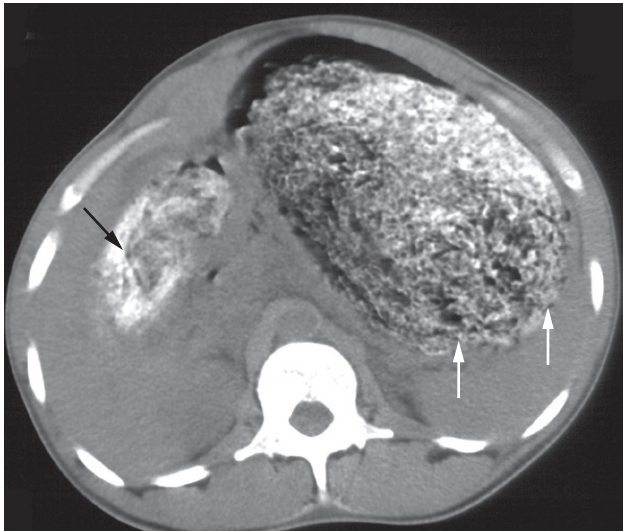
CT of a bezoar. The stomach is distended by a large mass of hair mixed with oral contrast (white arrows). The antrum is also distended by the ingested material (black arrow).
